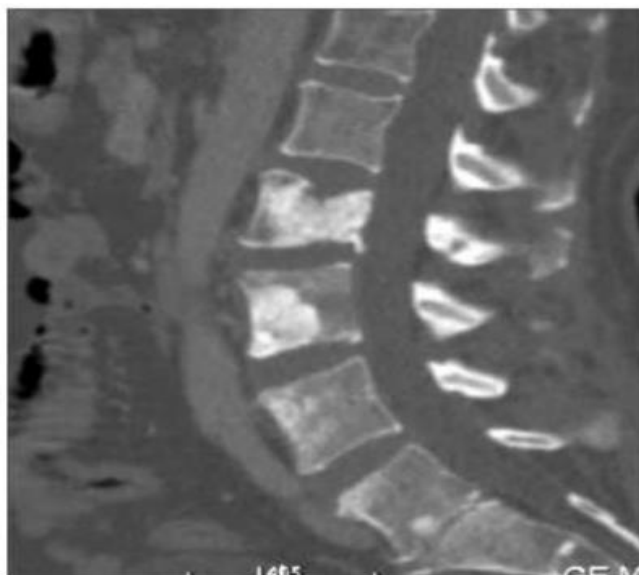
Bone window CT scan reconstructed in the sagittal plane. Staggered osteolytic spinal metastases, some of which invade the posterior wall [37].
